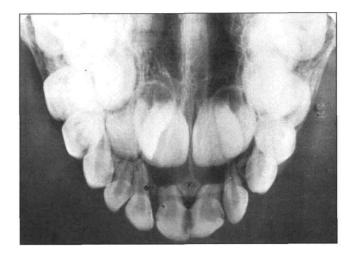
Radiograph of twin A showing the supplemental primary right maxillary incisor with an unerupted successional supplemental permanent right maxillary incisor.
